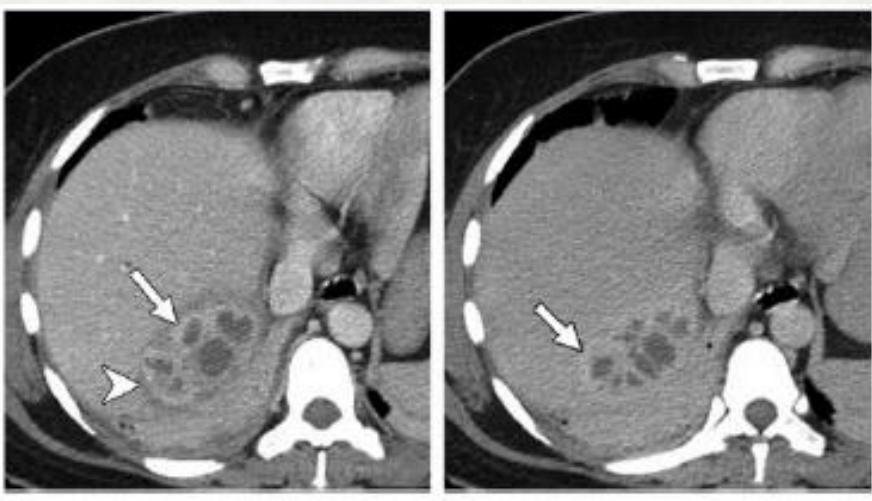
Pyogenic liver abscess in a 45-year-old woman who presented with fever and pleuritic chest pain. (a) Axial contrast-enhanced portal phase CT image shows a multilocular cystic mass in the posterior segment of the right hepatic lobe abutting the right hemidiaphragm. Note the layered wall ("double target sign"), with an internal enhancing pyogenic membrane (arrow) surrounded by hypoattenuating parenchymal edema (arrowhead). (b) Axial contrast-enhanced delayed phase CT image shows persistent enhancement of the inner layer, delayed enhancement of the outer layer (arrow), and a confluence of multiple small locules producing the "cluster sign."
